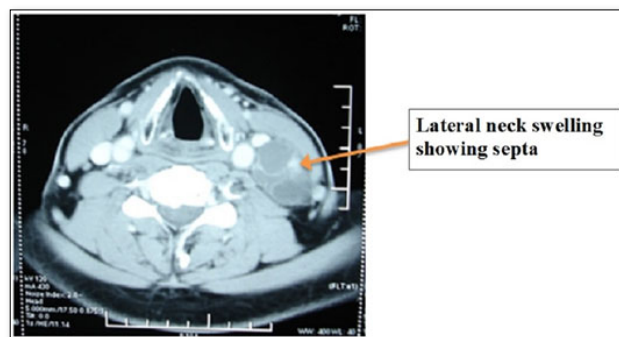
CT scan neck with contrast Axial View.
